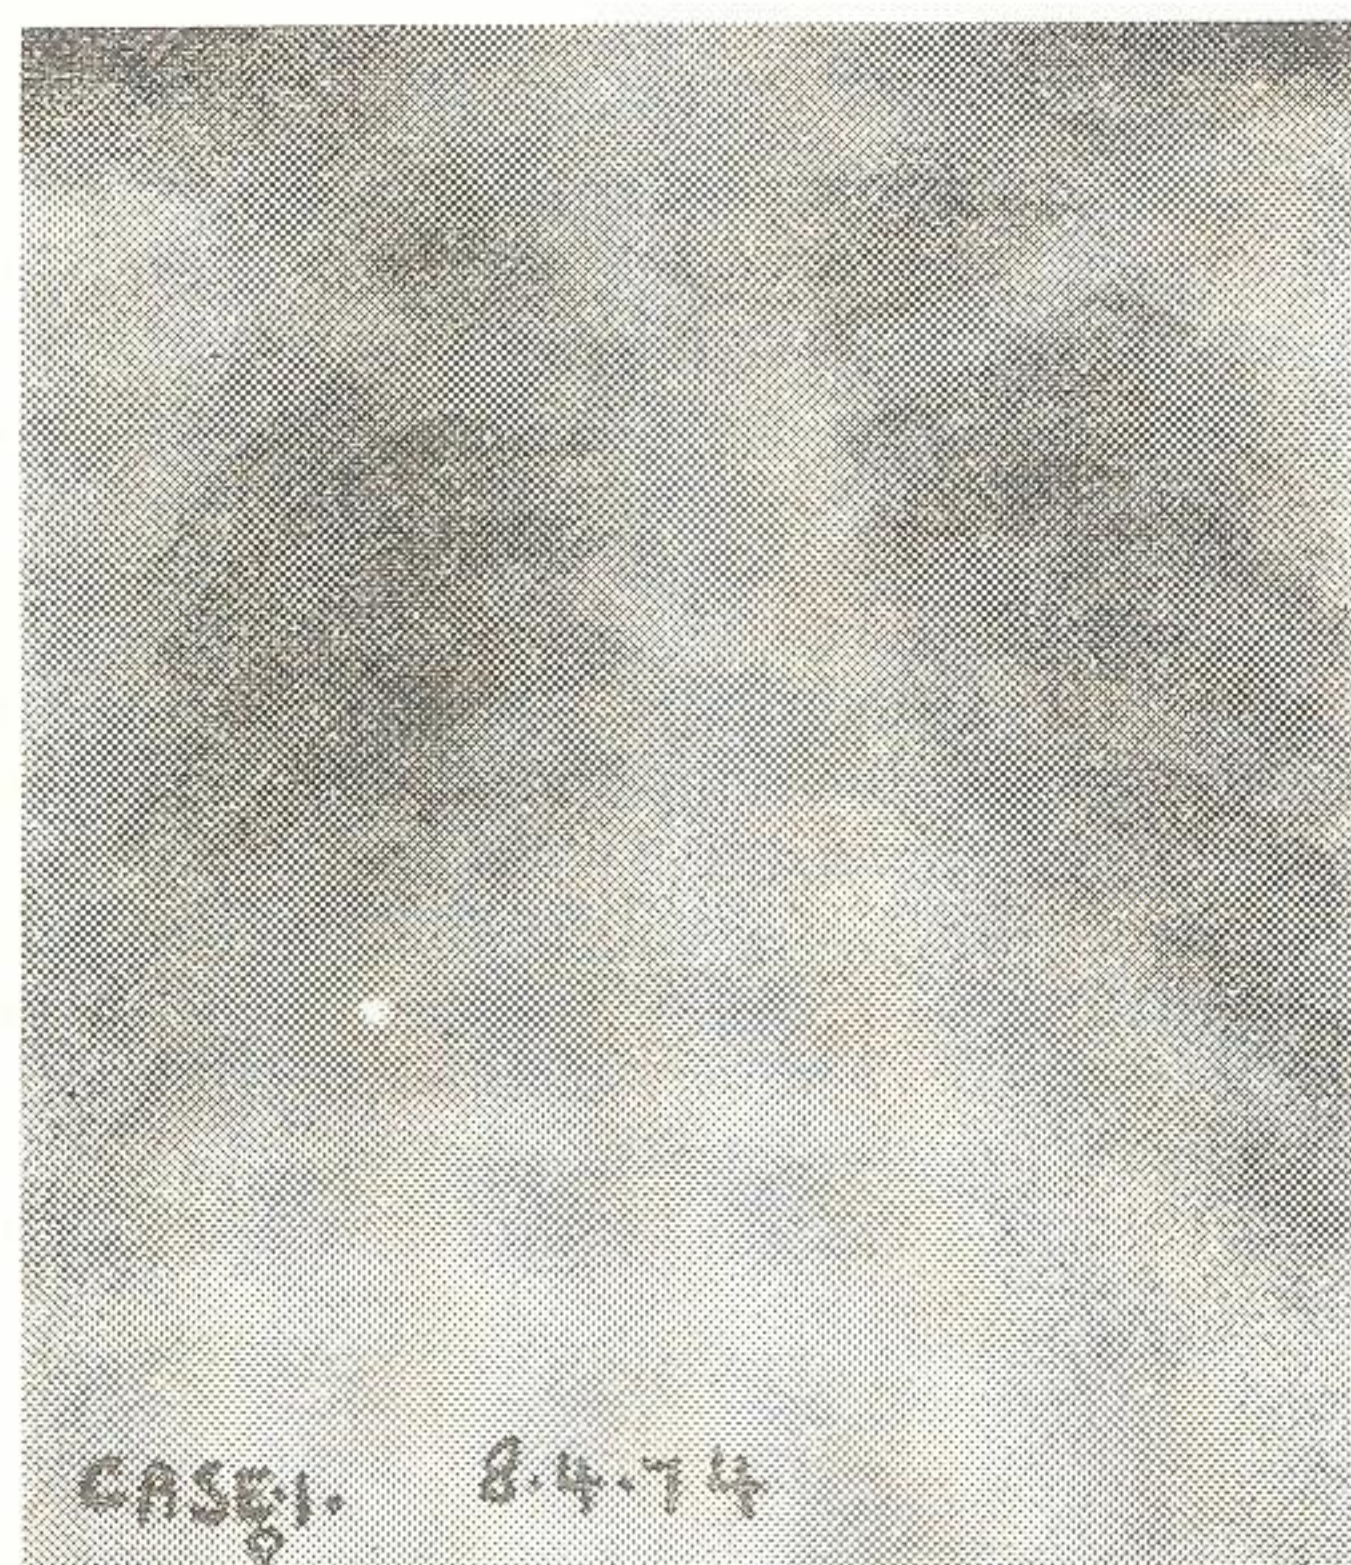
Case-1 (8-4-1974). X-ray chest P.A. view showing patchy consolidation at right base of the lung.
